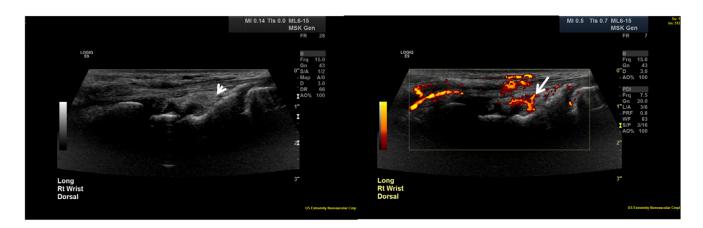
Grayscale and color Doppler sagittal images of the right wrist dorsally demonstrate synovial hypertrophy (arrowhead) with associated hypervascularity on color Doppler analysis (arrow). These findings are consistent with active synovitis.
